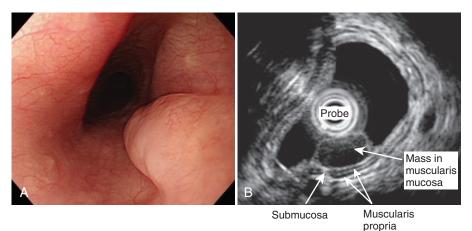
Esophageal leiomyoma. A, Endoscopic image shows an elongated submucosal lesion visible in the midesophagus. B, Endosonographic view using a 20-MHz catheter probe. The lesion is homogeneous, hypoechoic, and associated with muscularis mucosa.
